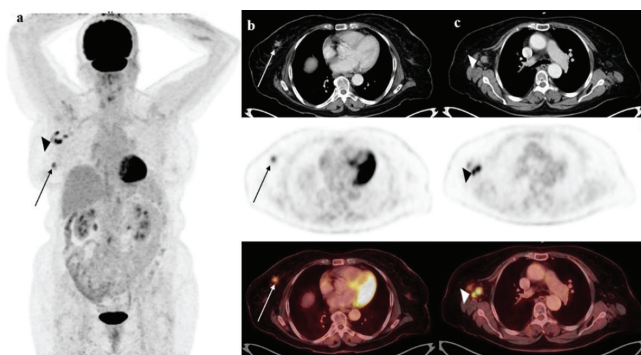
Seventy-six-year-old-female, stage IIIA 20% micropapillary component, 80% invasive ductal component breast cancer patient. Markedly hypermetabolic lesion located in the right breast was shown (SUV_{max} : 5.3 mg/dL; arrow). Metastatic axillary lymph nodes showed intense ^{18}F -FDG uptake (SUV_{max} : 10.1 mg/dL; arrow head).
